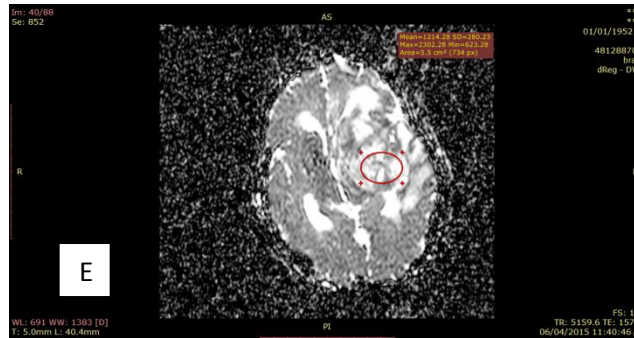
63-year-old male patient with left parietal mass (A. T1 axial; B.T2 axial; C.T1 axial postcontrast; D. DWI; E. ADC) showing ring enhancement and non-restricted diffusion with maximal ADC values (2.30 x10-3) confirmed by biopsy as GBM.
